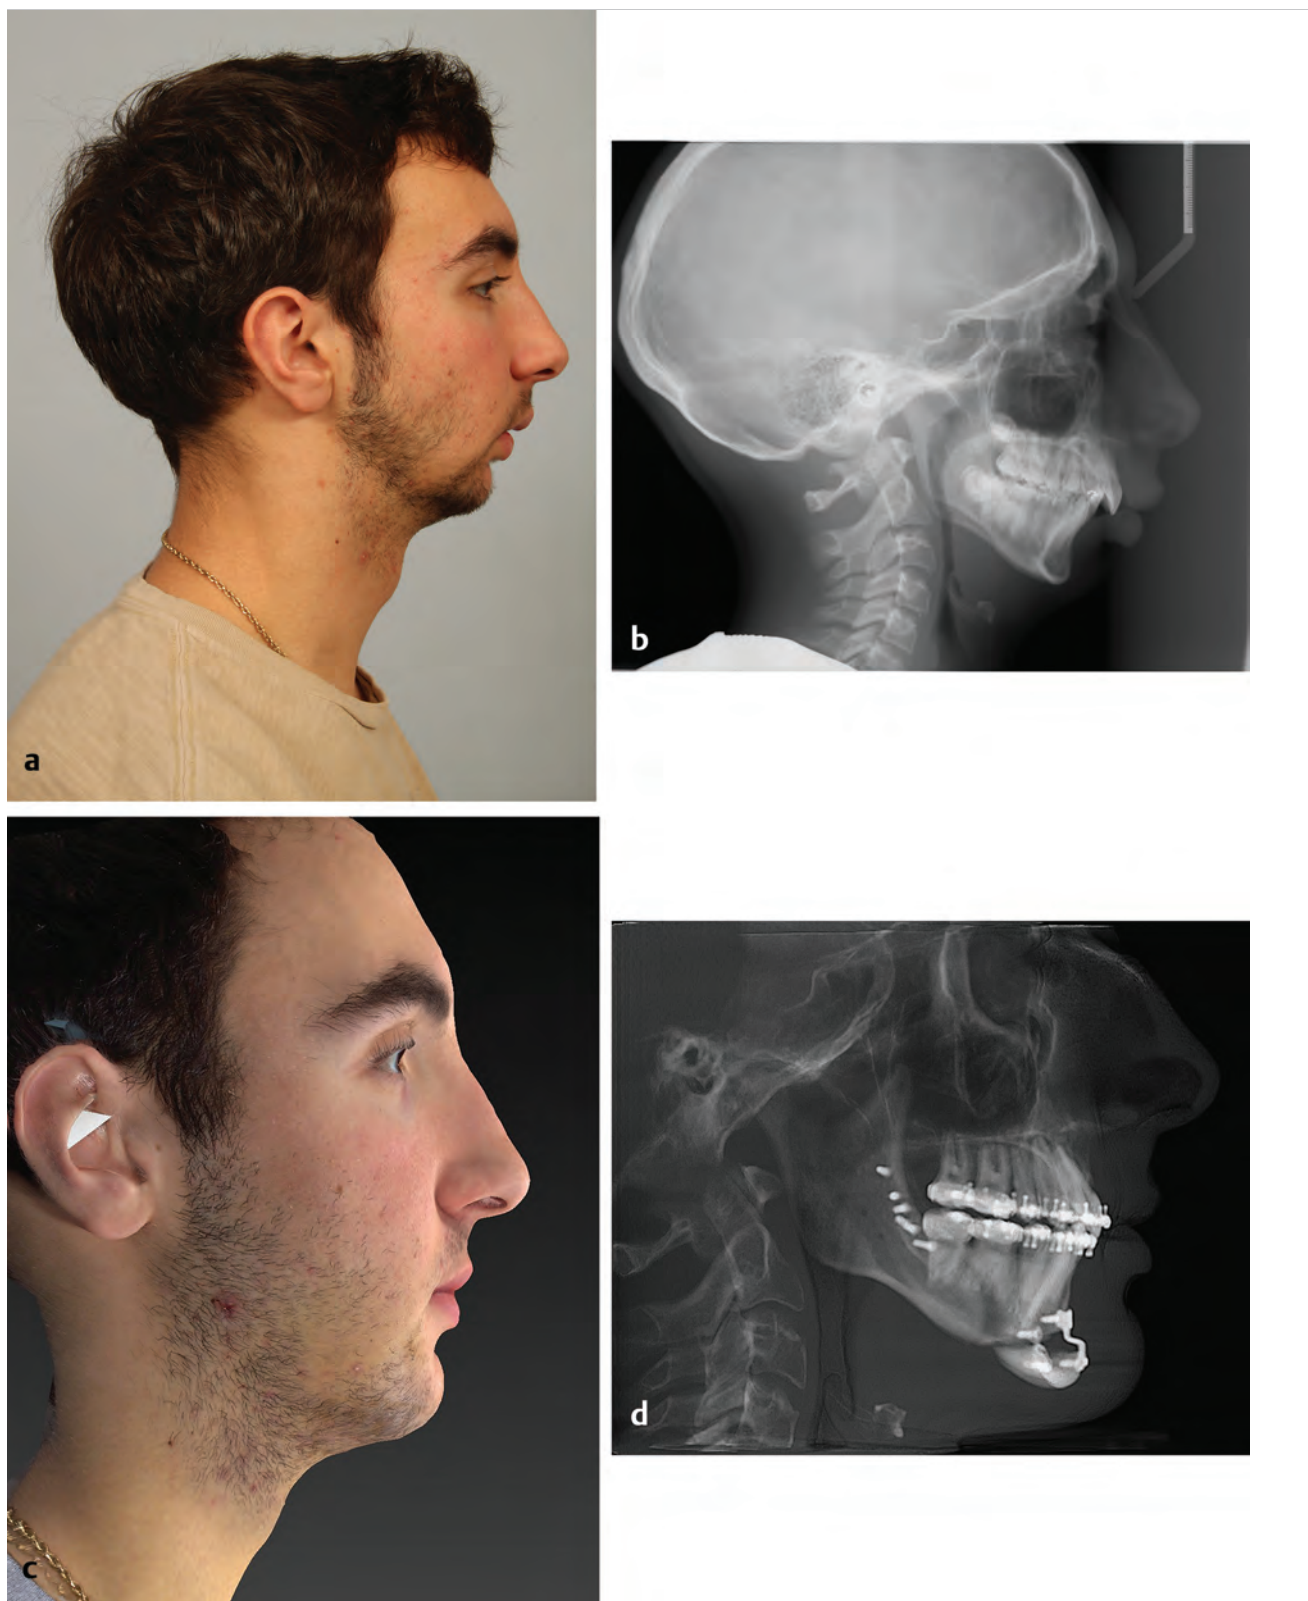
An 18-year-old man with a class II skeletal pattern. (a) Preoperative photograph demonstrating a retrognathic mandible with a convex facial profile. (b) Preoperative lateral cephalometric radiograph showing mandibular sagittal hypoplasia. (c,d) Postoperative three-dimensional photograph and radiograph after bilateral sagittal split osteotomy, with advancement of the mandible and advancing and lengthening genioplasty.
